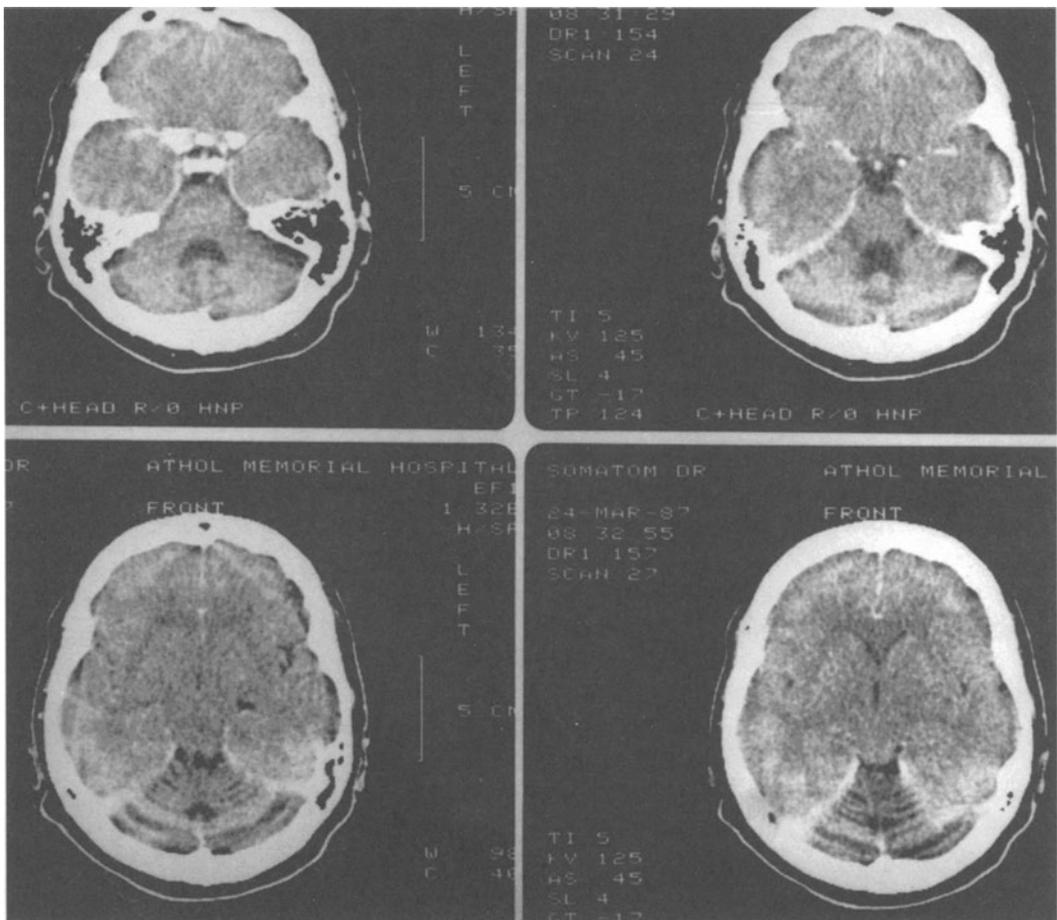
Generalized cerebellar atrophy most severe in the anterior superior vermis: CT scan. This 48-year-old female following an acute febrile illness and 3 weeks of coma at age 3 years, developed severe ataxia of stance and gait, with dysmetria on heel-to-shin testing, distal weakness in lower extremities and bilateral Babinski's signs.
